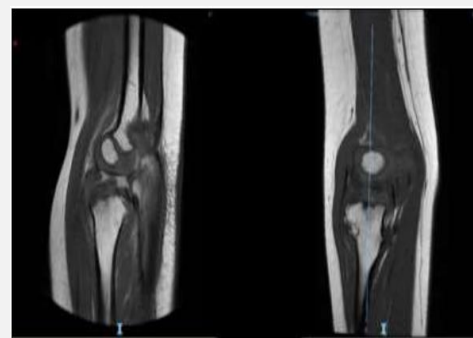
Sagittal and coronal T1 sequence MRI views, showing the morphology of the radial head.
